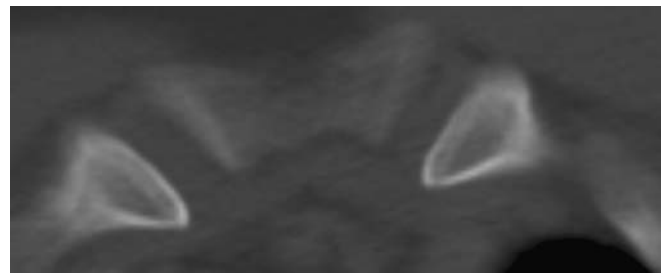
Reduced detail of a CT scan of ossification stage 4 of the medial clavicular epiphysis: epiphyseal cartilage fully ossified, epiphyseal scar visible (male 30.4 years)
